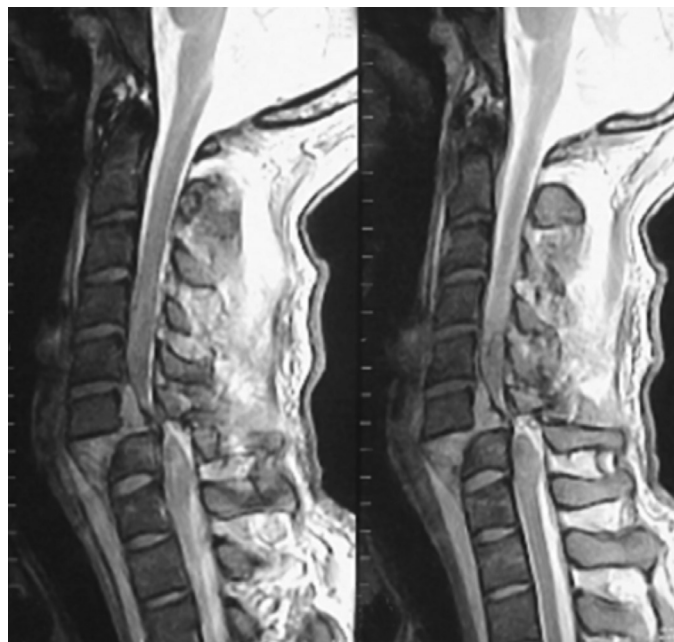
■ Sagittal T2-weighted MRI demonstrates a C6-C7 fracture-dislocation with severe cord compression in a patient who presented with complete C6 quadriplegia-ASIA.
